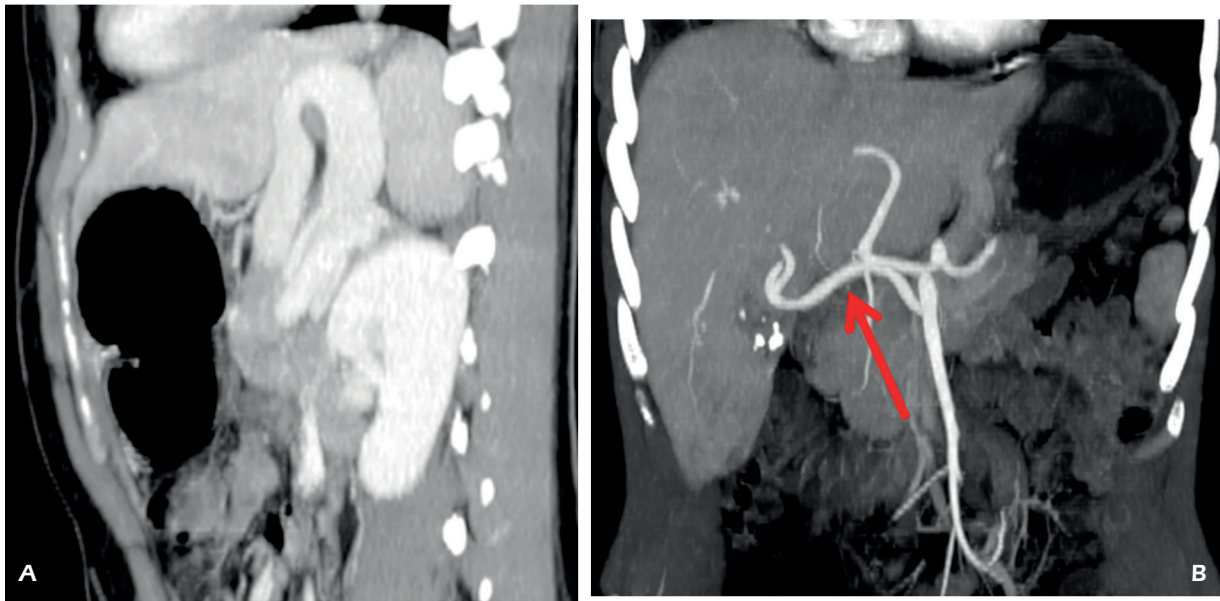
Congenital extrahepatic portosystemic shunts type 1b causing arterial hypertrophy. *A*, Axial contrast-enhanced CT shows absence of portal bifurcation and of intrahepatic portal branches. *B*, Coronal MIP reconstruction shows arterial hypertrophy, because of the complete loss of hepatic portal perfusion. A right hepatic artery from the superior mesenteric artery is present (*arrow*).
